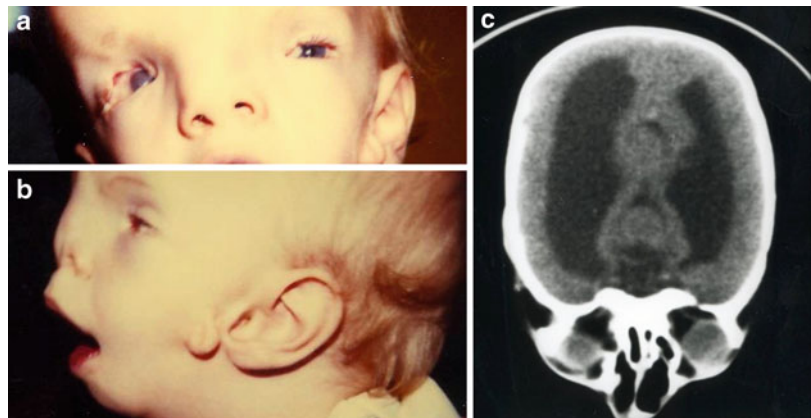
(a–c) An infant (a, b) with primidone embryopathy presenting as Goldenhar syndrome showing hemifacial microsomia, facial palsy, upper eyelid coloboma, epibulbar dermoid, and hydrocephaly by MRI (c)
